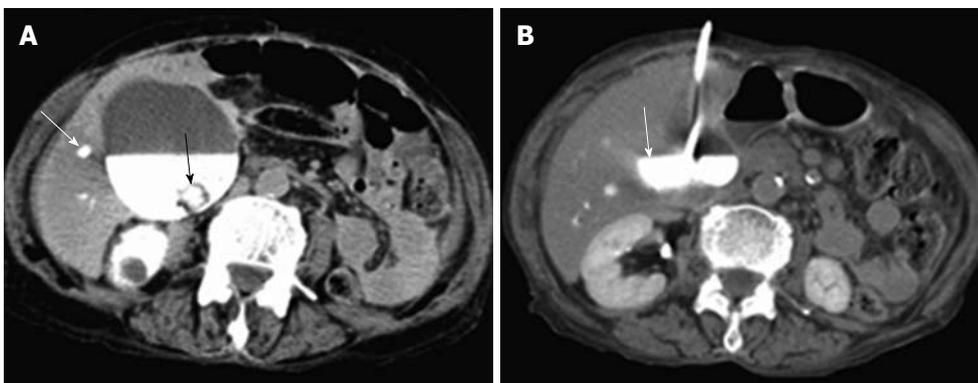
A case of gallbladder empyema. A: Computed tomography (CT)-guided cholecystostomy shows opacification of a markedly dilated gallbladder with intraluminal filling defect due to the presence of gallstones (black arrow). The intrahepatic biliary ducts (white arrow) were opacified after endoscopic retrograde cholangiopancreatography, which failed to drain the biliary ducts; B: Follow up CT scan shows well-drained gallbladder (arrow).
